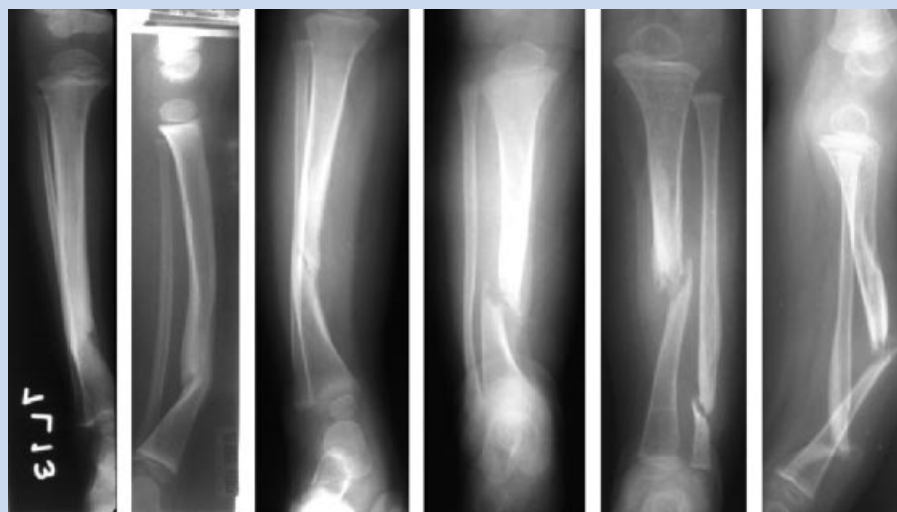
Radiographic examples showing different stages of fracture and pseudarthrosis of dysplastic long bones in individuals with NF1.
